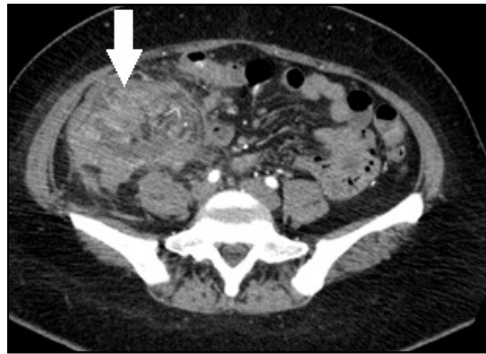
Contrast enhanced computed tomography of abdomen showing a large mass in the right side.
